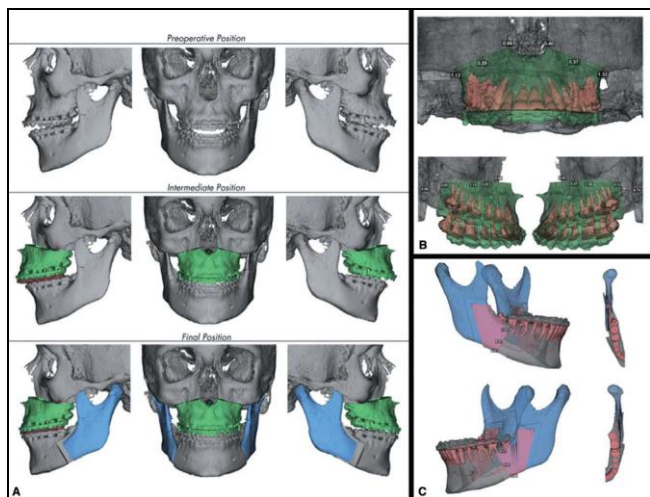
CBCT images of craniofacial anomalies
